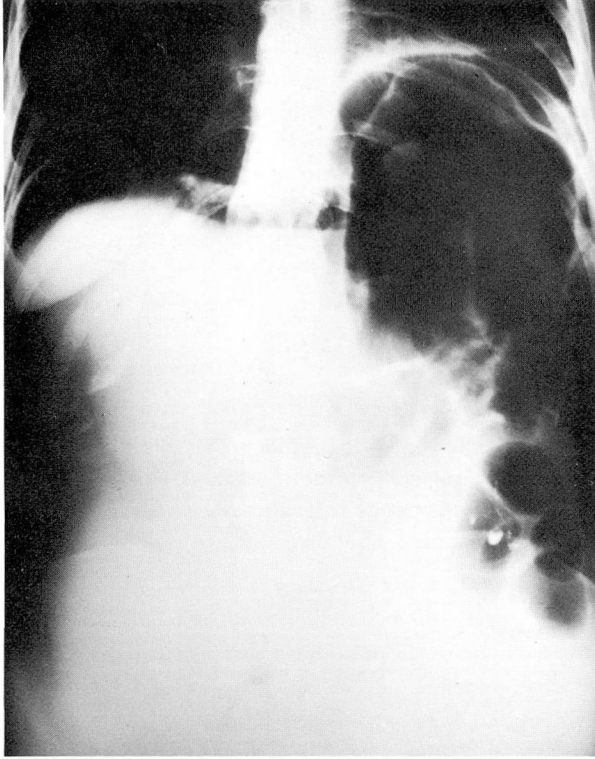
Roentgenogram of the abdomen on January 26, 1965, with the patient standing. Recurrent pneumoperitoneum and distention of bowel are evident. Barium is seen in three sigmoid diverticula.
